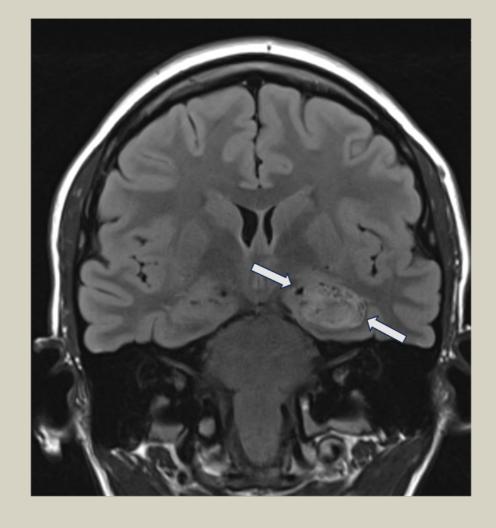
Magnetic resonance imaging showing a calcific mass protruding into the left temporal horn of the lateral ventricle.
